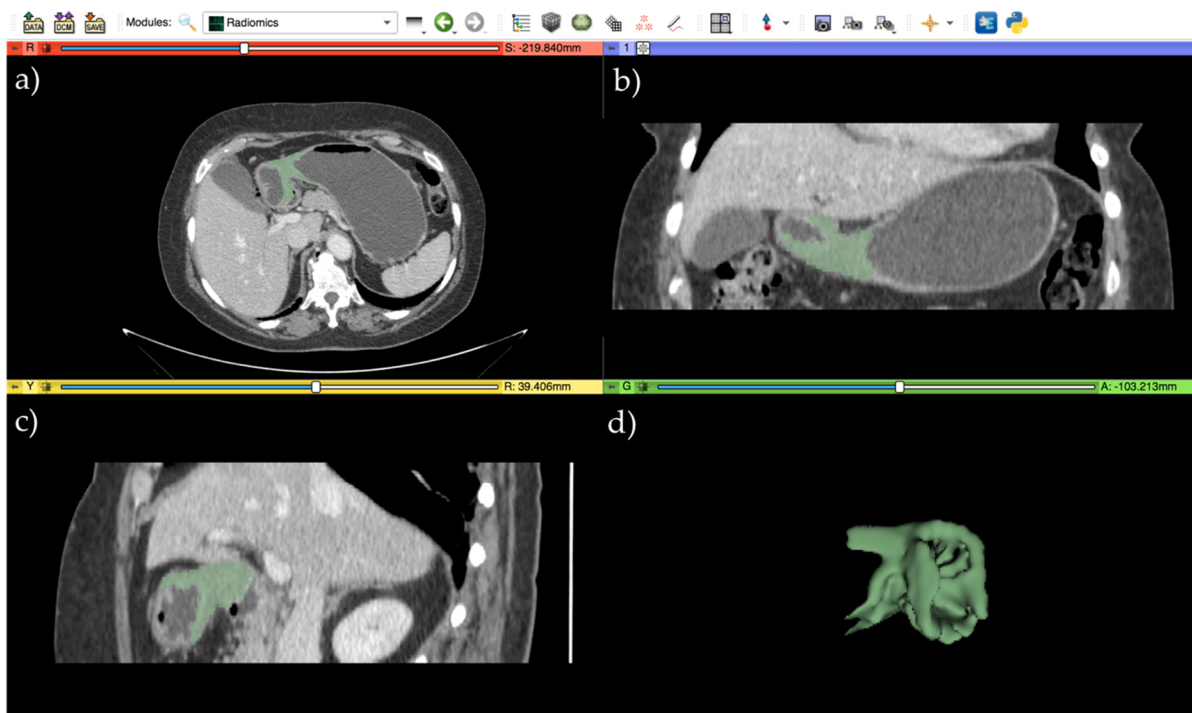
A volumetric manual segmentation performed with 3D Slicer software (version 4.10.2, <http://www.slicer.org> (accessed on 24 October 2020)) on a portal-venous phase CT scan of a 78-year-old woman with locally advanced gastric cancer after perioperative chemotherapy. (a–c) Axial, coronal, and sagittal plane views respectively. (d) The final 3D representation of the whole tumor segment, avoiding the surrounding healthy mucosa, gas, and perigastric fat.
